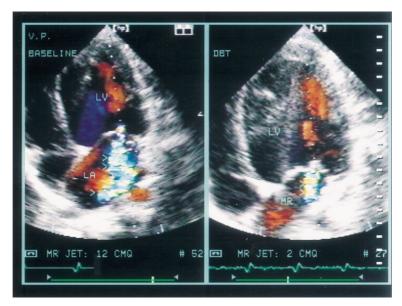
Improvement in MR during DET in a study patient with IDCM. At baseline colour-Doppler study (left frame), MR was moderately severe  $(3 + ; MR \text{ jet area} = 12 \text{ cm}^2)$ . During DET (right frame), MR was only mild  $(1 + ; MR \text{ jet area} = 2 \text{ cm}^2)$ .
